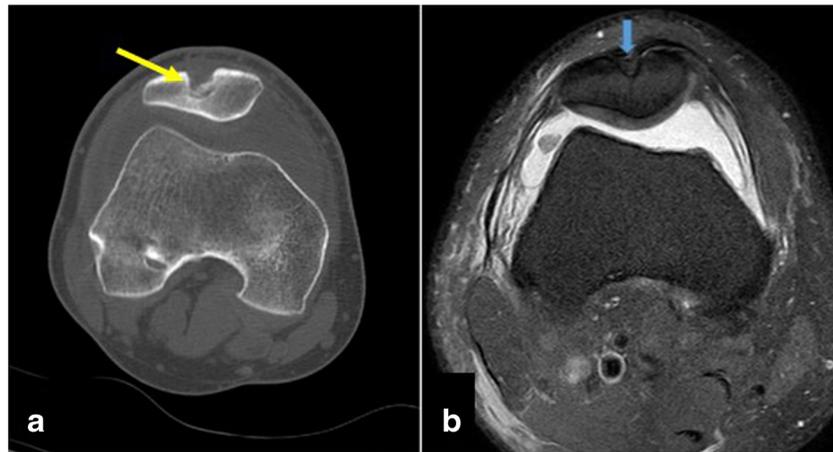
Image of QTB graft harvesting: a axial CT image showing central tendon quadriceps harvesting with bone block; b T2 proton density fat saturation MRI axial image showing a groove over the patella indicating the patella bone block harvest site (blue arrow). Image a was provided
